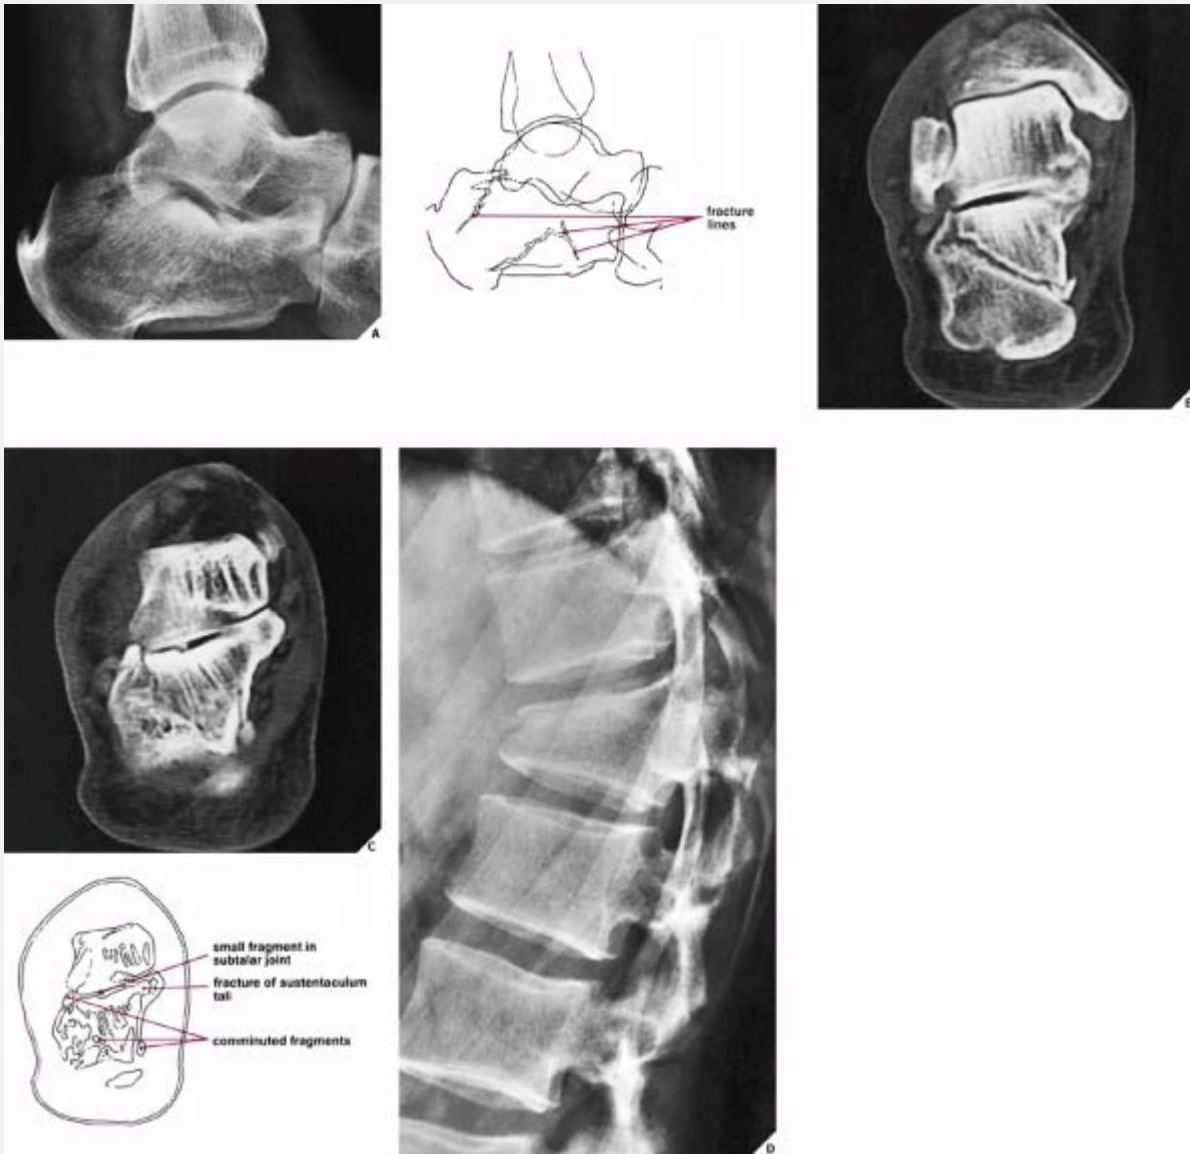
Fracture of the calcaneus. A 54-year-old man fell from a scaffold and sustained a fracture of the left calcaneus. (A) Lateral view shows a comminuted fracture of the calcaneus. There is a suggestion of extension of the fracture line into the subtalar joint. (B) Tomographic examination in the lateral projection confirms intraarticular extension of the fracture line. The amount of depression of the articular surface, however, cannot be definitely assessed. (C) CT section precisely demonstrates the position of the comminuted fragments and depression at the posterior facet of the subtalar joint. It also shows that the middle facet is intact, important information that the conventional and tomographic studies could not provide.
